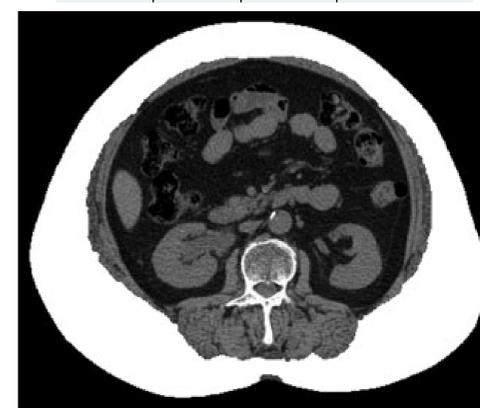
CT measurement of VAT (left) and SAT (right) displayed in white.<sup>1</sup>
